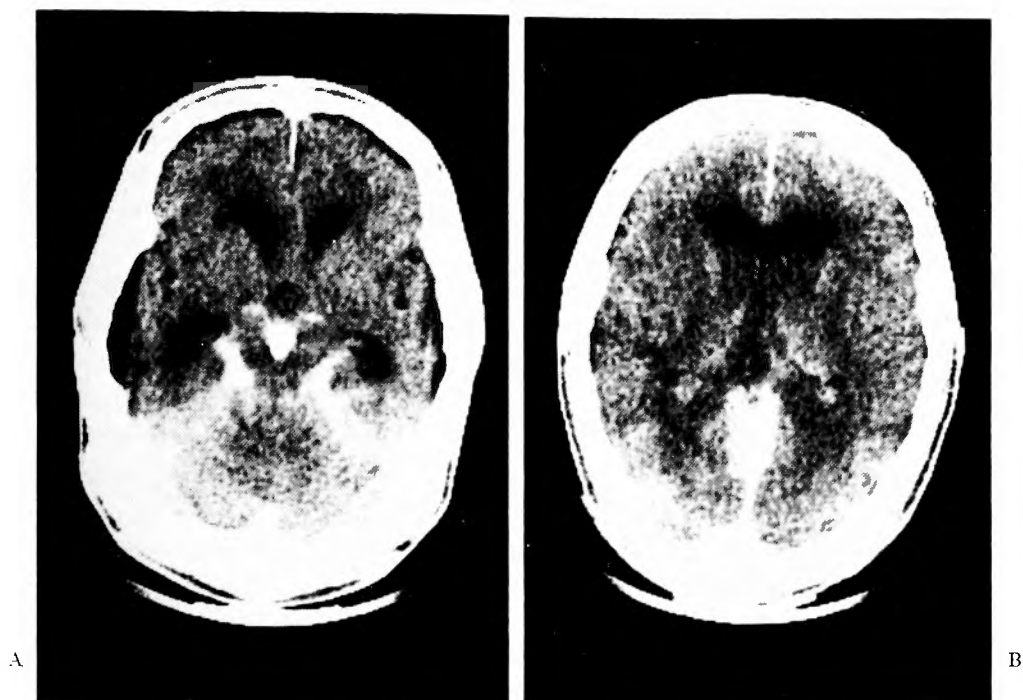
Post-angiographic CT scan.
